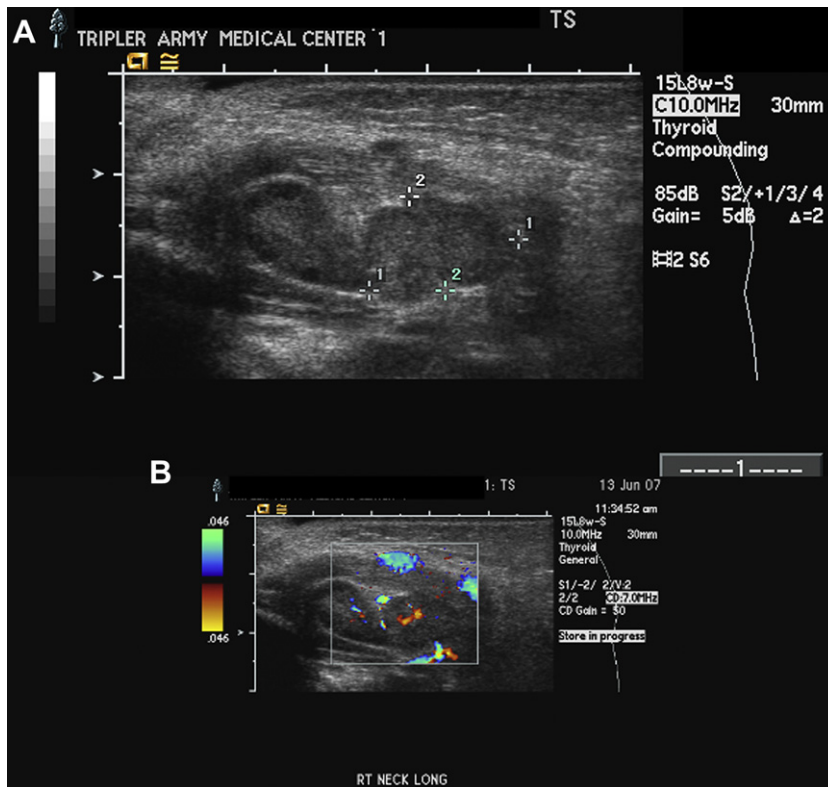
(A) Five-month-old with fevers to 103°F for 36 hours with increased swelling of right neck. Screening ultrasound images demonstrate bilobed solid structures with hypoechoic peripheral parenchyma and central increased hilar echogenicity, consistent with a reactive lymph node. (B) Central color Doppler flow is noted, characteristic for a lymph node. Electronic calipers allow incremental follow-up to the scale of a millimeter.
